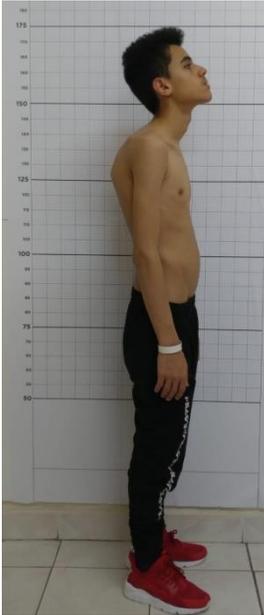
Body position in x-ray exam (orthoroentgenogram) for thoracic kyphosis
